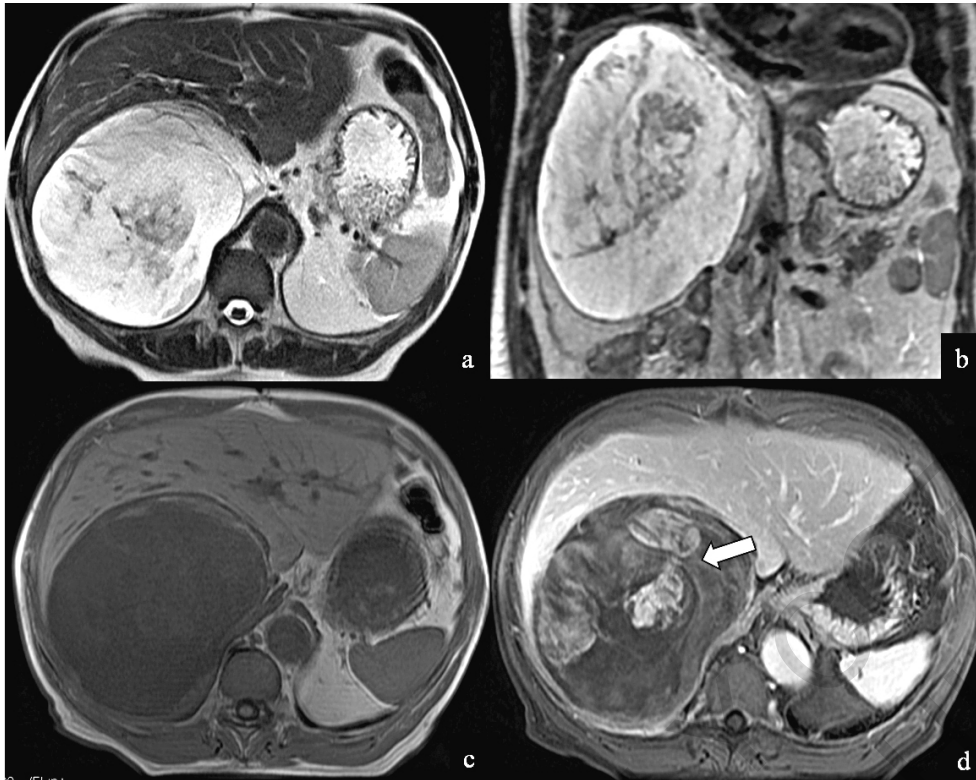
Myxoid liposarcoma. Axial (a) and coronal (b) T2-weighted, axial T1-weighted (c), and axial contrast enhanced fat saturation T1-weighted MR images reveal right retroperitoneal encapsulated mass. The mass shows high signal intensity at T2-weighted and low signal intensity at T1-weighted due to the extracellular myxoid matrix, and patchy areas of enhancement at contrast enhanced fat saturation T1-weighted indicative of solid component (arrow).
